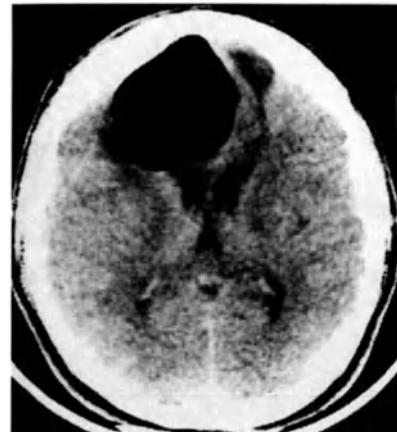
CT demonstrates right frontal aerocele following frontal fracture involving the frontal sinus.
